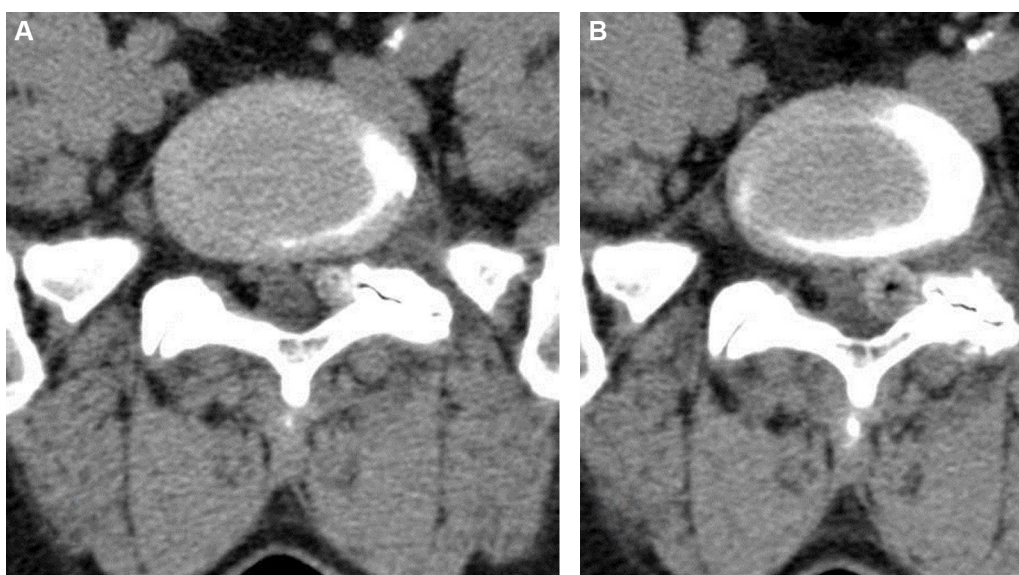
(A, B) The first axial CT (A) obtained 4 months after starting the symptoms of the patients. The first CT exam (A) shows a hyperdens nodular lesion adjacent to facet joints which has degenerative joint disease. The second CT (B) exam obtained one month after to the first exam shows the enlarged nodular structure contains vacume phenomena similar to intraarticular air of left facet joint space.
